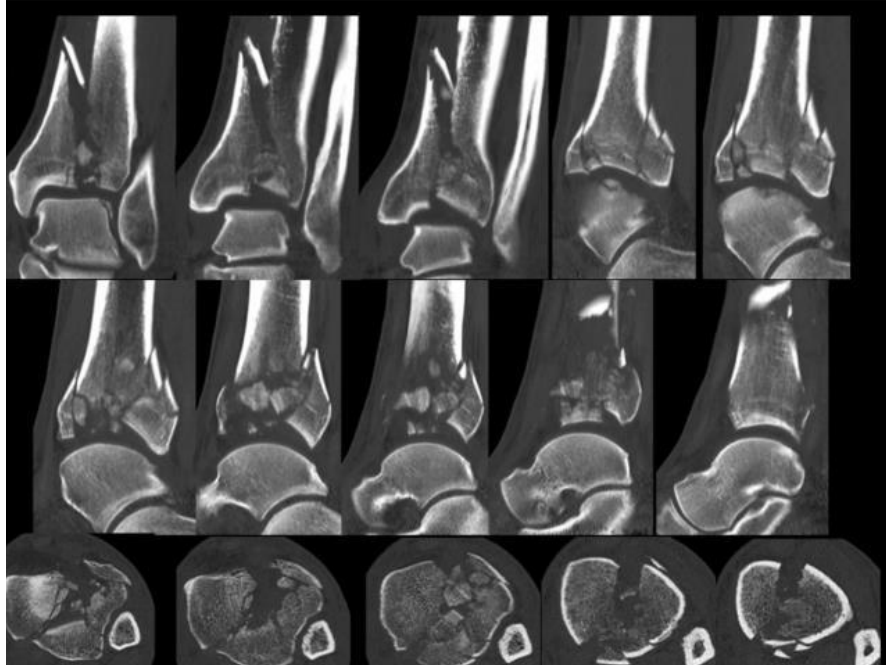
Computed tomography scan of complex distal tibia fracture with the articular surface in more than 2 pieces (10).
